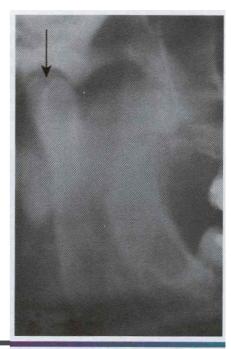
• Bifid condyle. Radiograph of the mandibular condyle showing a double head (arrow). (Courtesy of Dr. Ed McGaha.)
